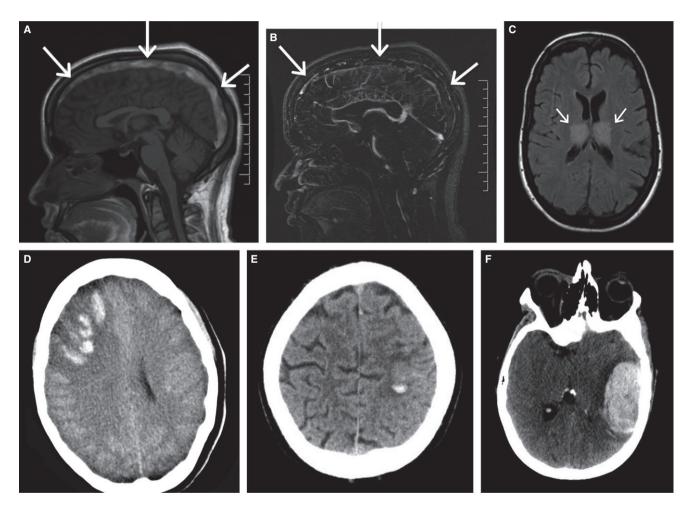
Imaging findings in patients with cerebral venous thrombosis (CVT). (A, B) Magnetic resonance imaging (MRI) of a 20-year-old male with thrombosis of the superior sagittal sinus. The sagittal T1 sequence (A) shows a hyperintense signal in the superior sagittal sinus, due to methemoglobin in the thrombus (arrows). On the corresponding contrast enhanced MR-venography (B), there is no filling visible of the superior sagittal sinus (arrows). (C) Axial MRI (fluid-attenuated inversion recovery [FLAIR] sequence) of a 43-year-old patient with thrombosis of the deep venous system. A hyperintense signal is present in both thalami (arrows) indicating edema. Clinically, the patient had a mildly decreased consciousness (E4M6V4). (D) Axial non-contrast enhanced computerized tomography (CT) scan of a patient with CVT showing a parenchymal lesion in the right hemisphere. Within the large hypodense area (dark; edema), patchy hyperdense (white) areas are visible, which are hemorrhages. Such lesions are generally termed venous hemorrhagic infarct. (E) Small juxtacortical hemorrhage (JCH) in the left hemisphere of a patient with CVT. Note how the hemorrhage is located just below the cortex and how it follows its curvature. There also is a small amount of edema (darker areas) surrounding the hemorrhage, although this can be hard to visualize on CT. These JCHs are almost exclusively seen in patients with thrombosis of the superior sagittal sinus. (F) Large intracerebral hemorrhage (ICH) in the left temporal lobe in a 52-year-old patient. She had a global aphasia and a right-sided hemiparesis. This patient had an occlusion of Labbé's vein. Sometimes, these ICHs are mistaken for an arterial bleed.
